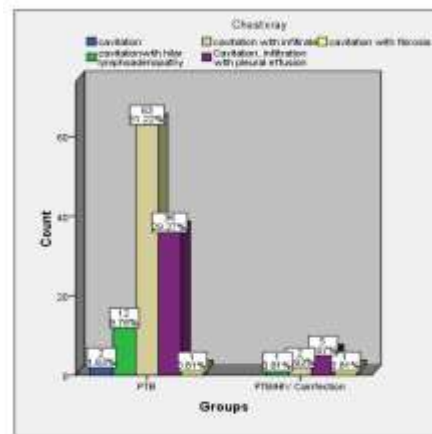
Radiological findings on chest X-ray in PTB and PTB/HIV Co-infection
